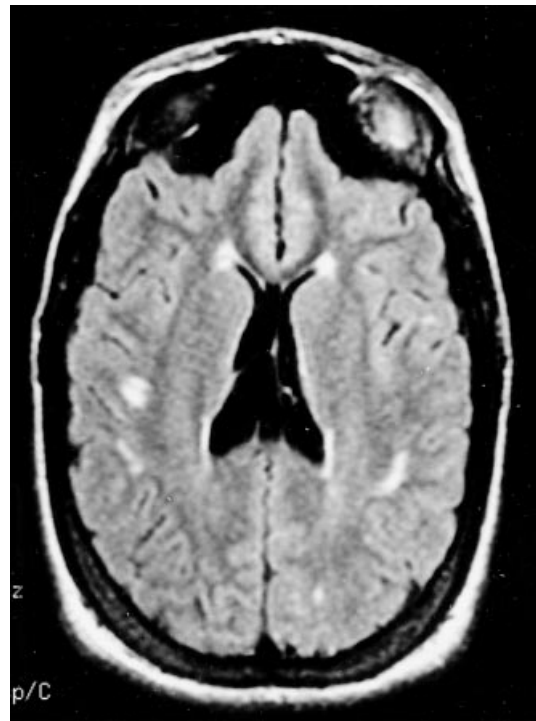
Subcortical lesions. An axial FLAIR sequence demonstrates increased signal within the periventricular white matter, which are predominantly subcortical.
